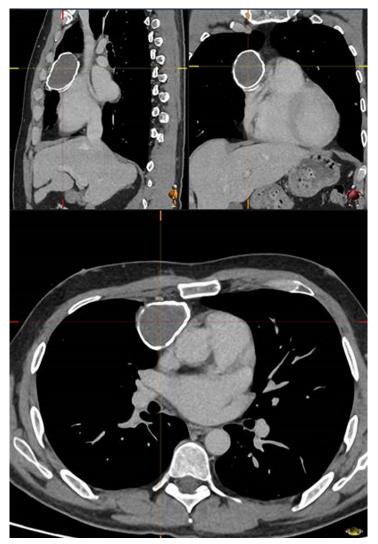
Preoperative computed tomography demonstrating a large right-sided paramediastinal mass with a calcified wall.
